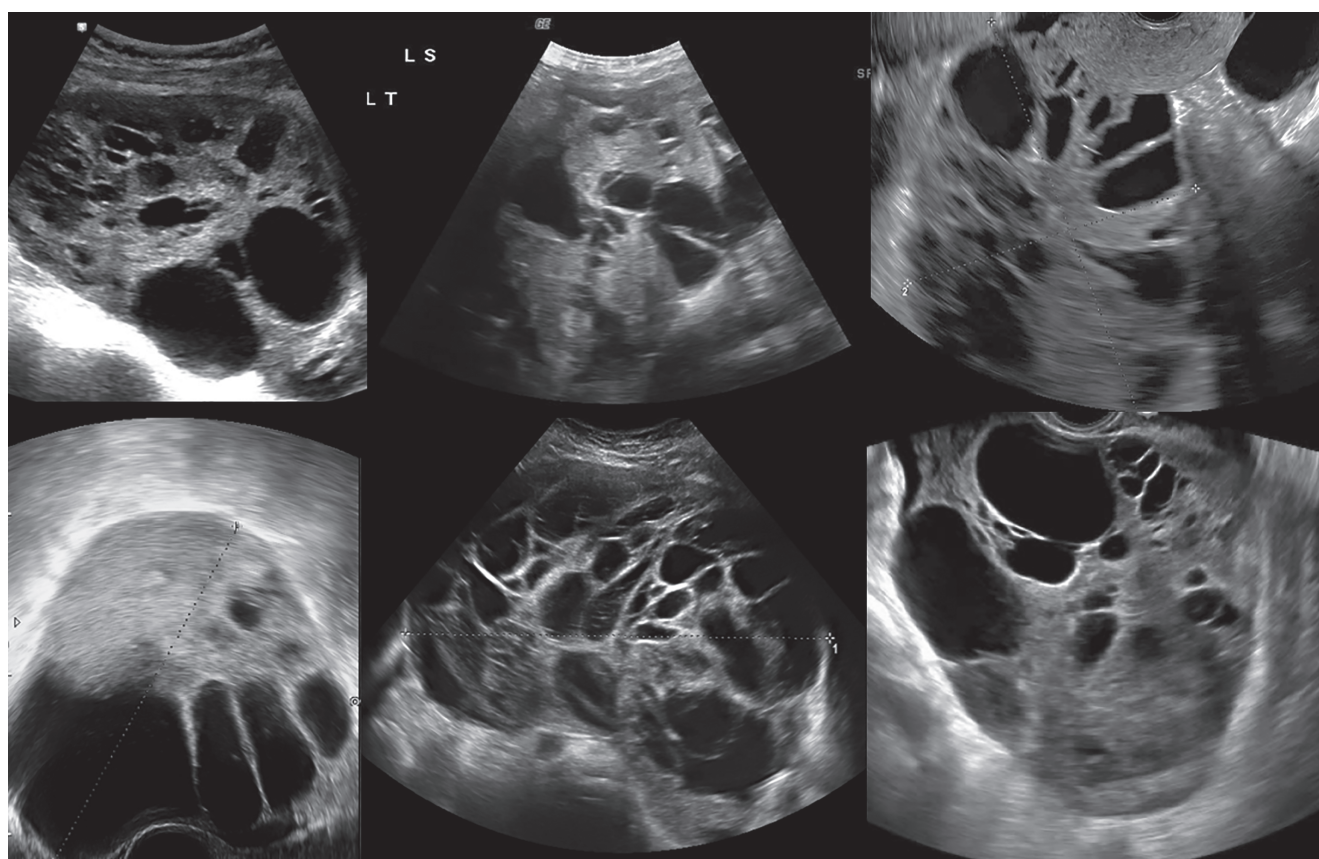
Ultrasound images of six different multilocular-solid ovarian yolk sac tumors.
